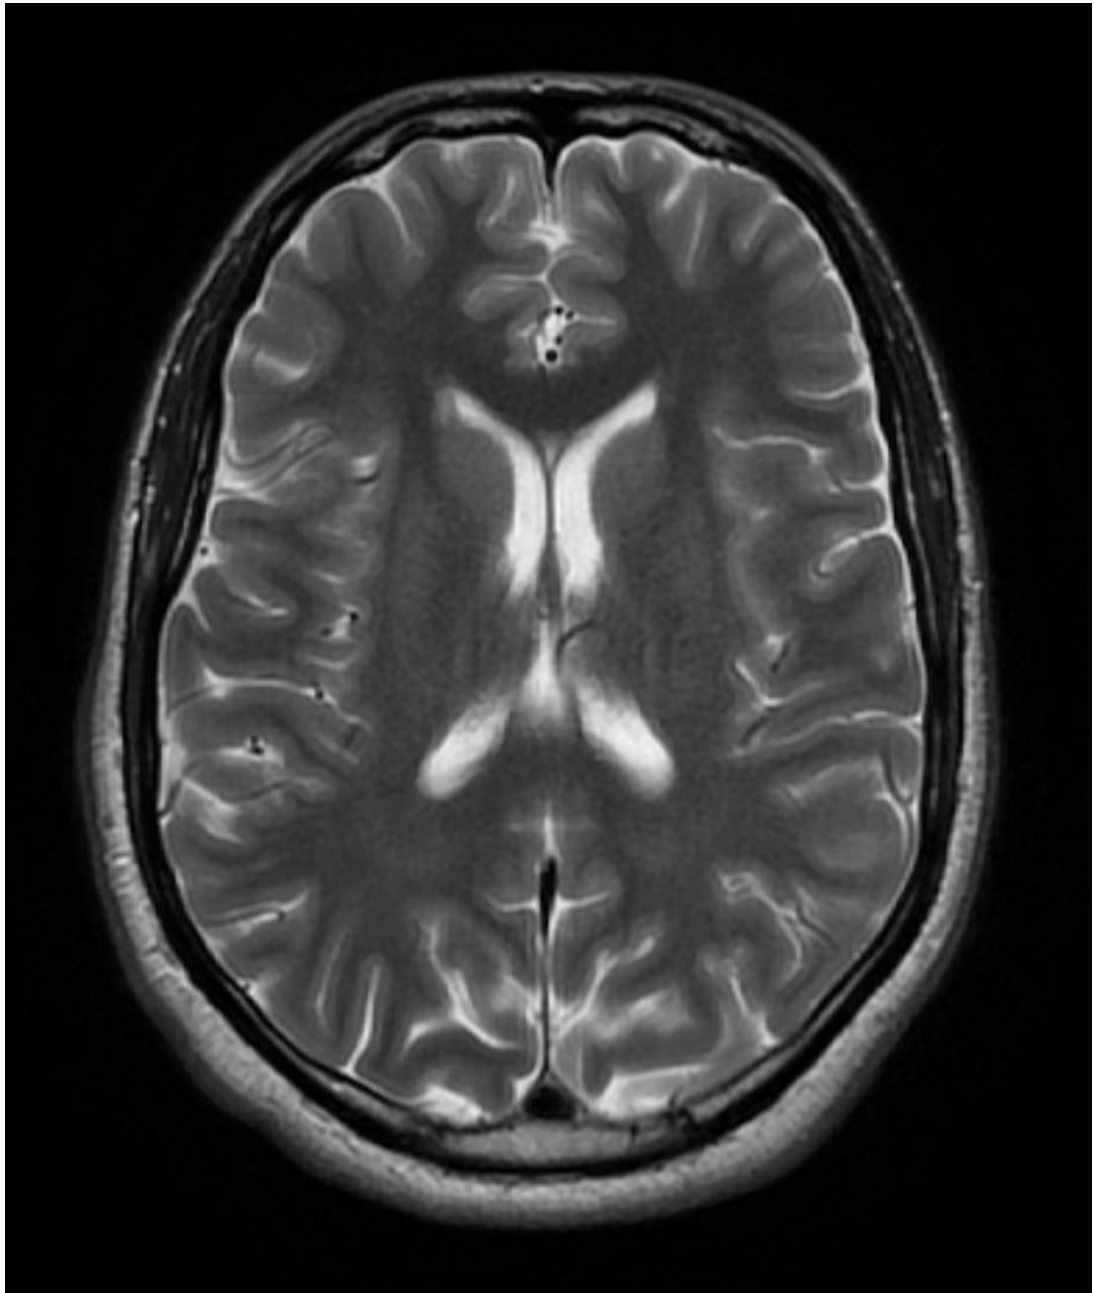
Axial MRI of DII.1 skull, demonstrating no occipital skull defect. (Thanks to Dr Indran Davagnanam (Dept of radiology, Moorfields Eye Hospital) for images and report).
